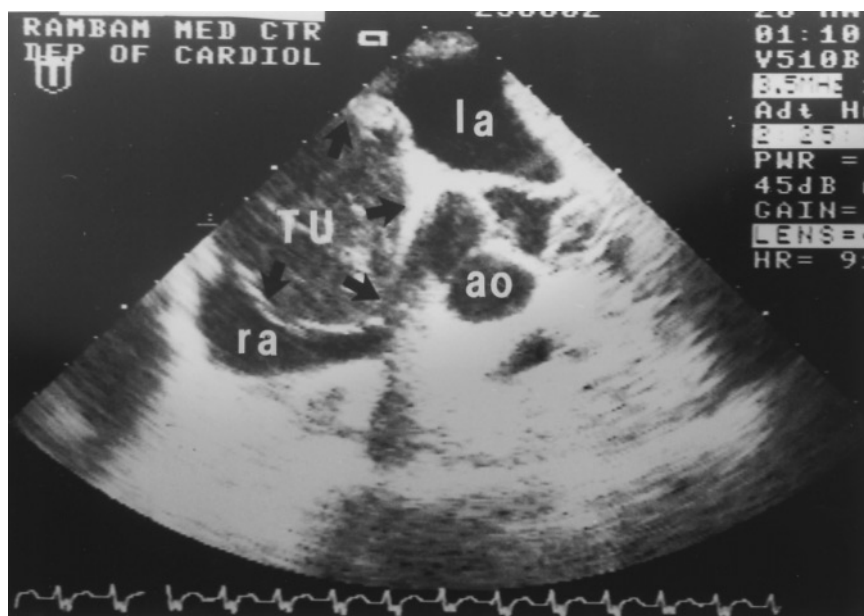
A transesophageal echocardiographic study demonstrating a large echogenic mass occupying the right atrium and penetrating into the right atrial wall. TU = tumor; la = left atrium; ao = aorta; ra = right atrium.
